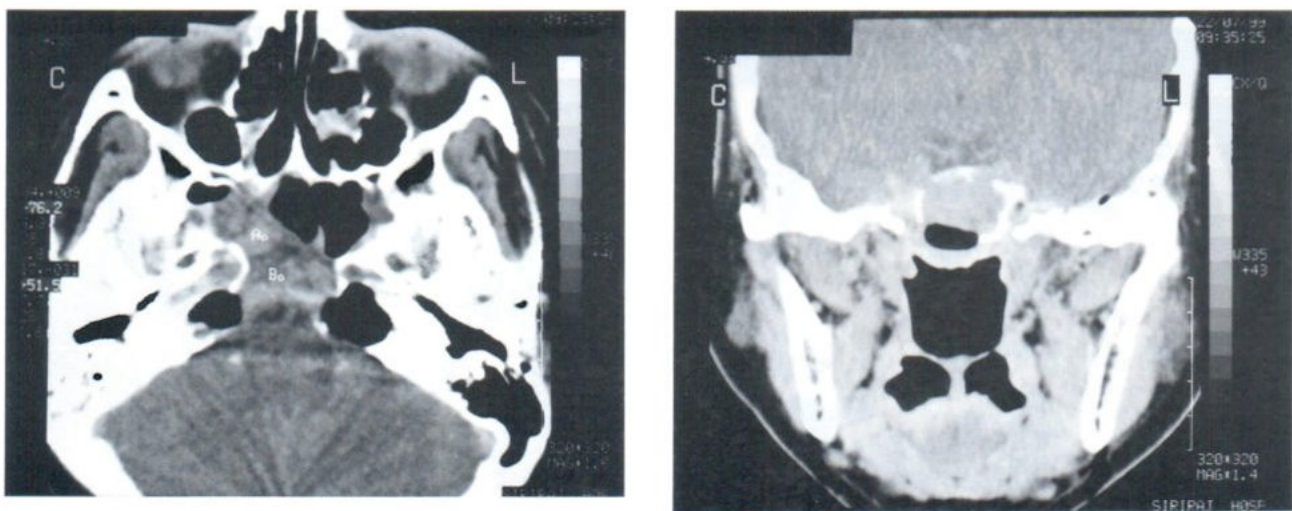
Axial and sagittal CT images 2 months after the second SRT treatment showed significant decrease in size of the suprasella lesion but there was still large residual tumor in the nasopharynx, sphenoid and ethmoid sinuses
